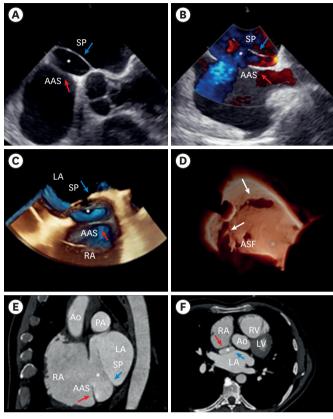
(A) TEE at 0° revealing two parallel septal structures creating an echo free IAS with 14 mm between them. The IAS is in a phase of expansion, as blood enters the cavity from the left atrium during ventricular systole. (B) Midesophageal bicaval view with color Doppler showing a shunt between IAS and RA through a septal defect (28 × 33 mm) at the middle segment of AAS, and with LA through the ASF and 2 main septal defects present in SP. (C) 3D TEE exhibiting the IAS between atria, with no thrombus. (D) 3D TEE showing the SP with ASF and the 2 main septal defects (the superior with major axis of 16 mm and the inferior with 19 mm) (white arrow). (E, F) Multiplanar computed tomography reconstructions in both coronal and axial planes revealing the IAS (*) with the main septal defects in both interatrial septa (E). Blue arrow: septum primum: Red arrow: accessory atrial septum. AAS: accessory atrial septum, AO: aorta, ASF: atrial septal fenestrations, IAS: interatrial space, LA: left atrium, LV: left ventricular, PA: pulmonary artery, RA: right atrium, RV: right ventricular, SP: septum primum, TEE: transesophageal echocardiogram, 3D: three-dimensional.
